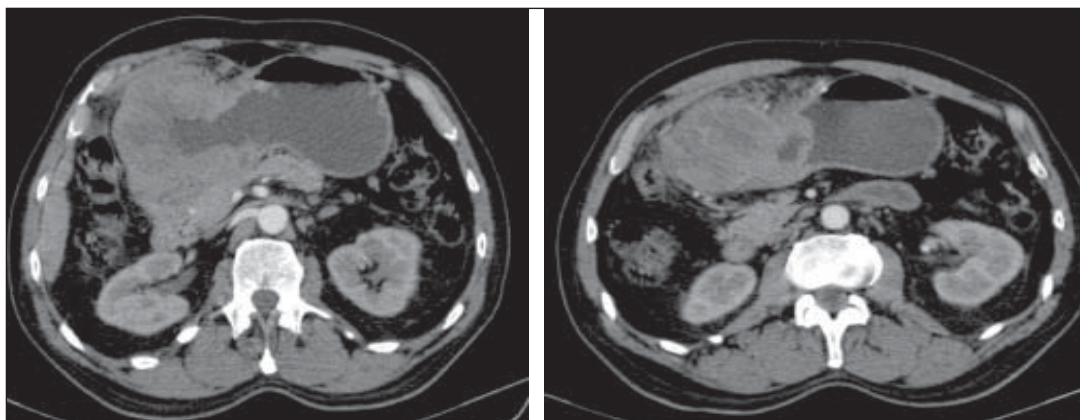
Contrast-enhanced whole abdomen CT, axial sections.
